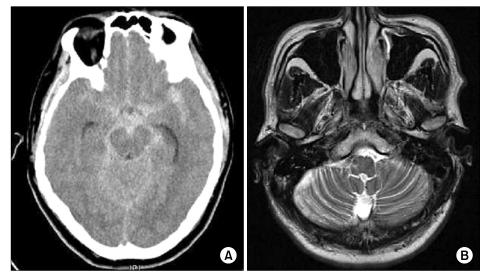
Brain images of the patient. (A) Initial computed tomography image shows high density in basal cistern. (B) Axial T2-weighted magnetic resonance imaging shows high signal intensity in right lateral side of medulla.
